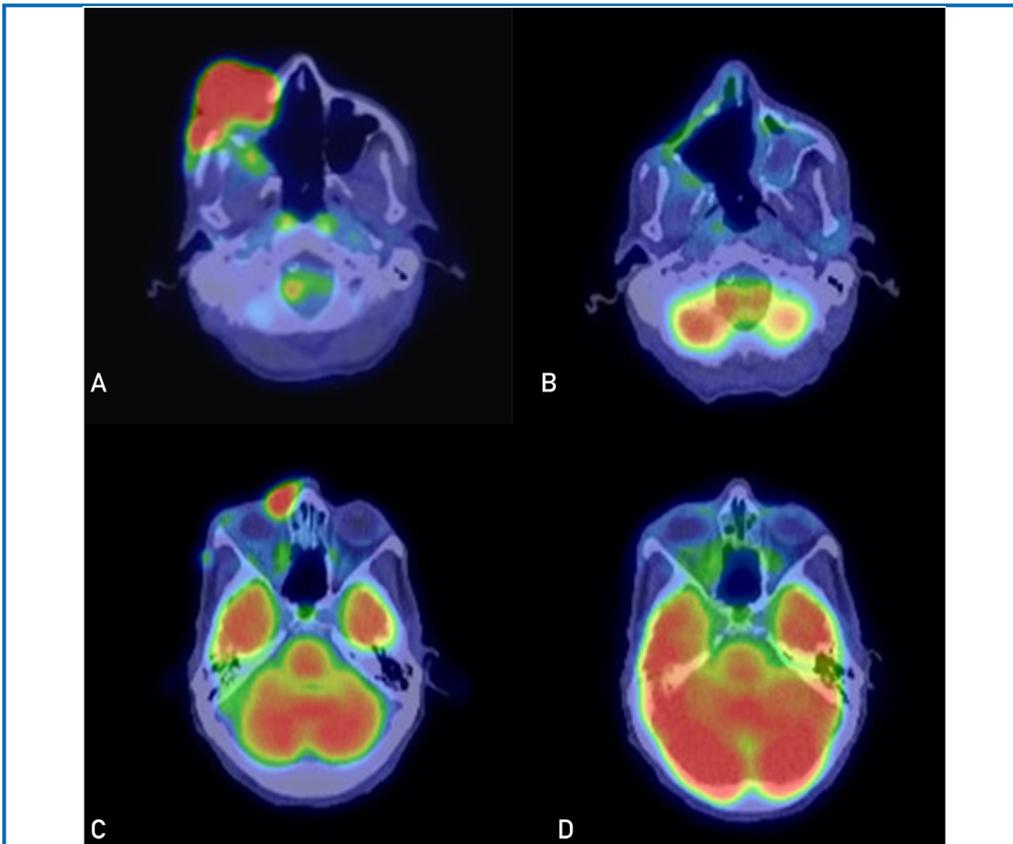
Positron emission tomography/computed tomography (PET/CT) images show complete metabolic response of recurrent mucosal melanoma after minibeam radiation therapy (MBRT). (A) Initial PET/CT 1 week before first MBRT treatment shows a large enhancing mass in the right inferior orbit. (B) Subsequent tumor response 13 weeks after MBRT. (C) Initial PET/CT showing enhancing mass in the right upper medial orbit 10 days before the second course of MBRT. (D) Subsequent tumor response 7 weeks after the second MBRT treatment to the right upper medial orbit.
